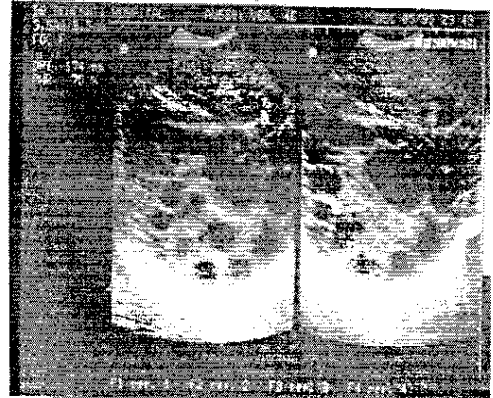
Ultrasound image of a hydatid cyst in the liver showing daughter cysts
